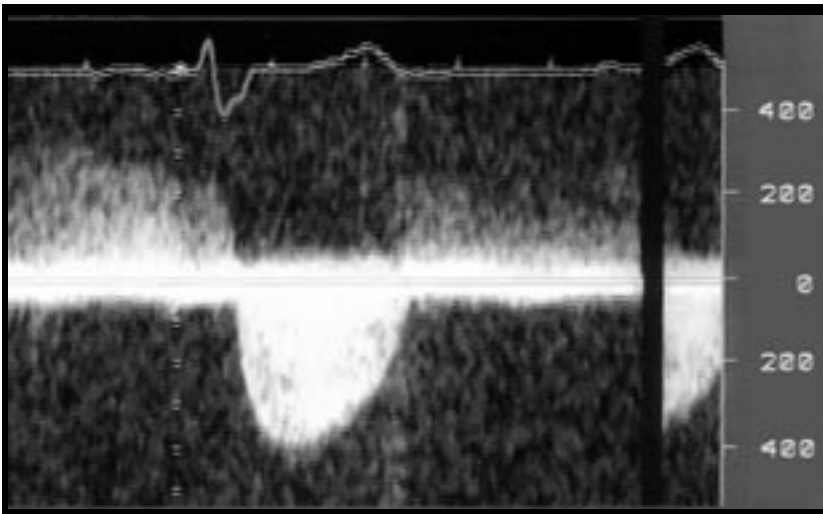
A transthoracic echocardiogram depicting peak aortic valve velocity 420 cm/sec, mean gradient 48 mmHg, and aortic valve area is 0.45 cm² compatible with severe aortic stenosis (April, 2006)
